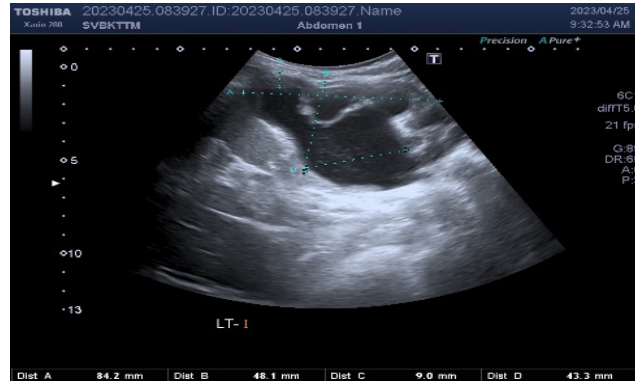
Sonogram of a patient with grade III megaureter
